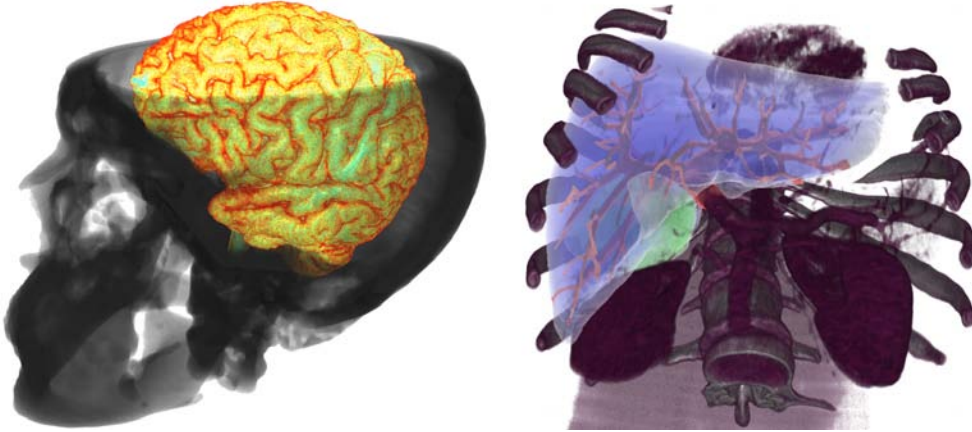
Most relevant scenes for real medical applications are used as test cases C2 (left) and C7 (right). C2 shows a skull acquired as CT scan with a brain acquired as MRI. C7 is a volume of the abdomen, combined with a 10k polygonal model representing the liver surface, a 30k polygonal model representing the liver portal vessel tree and a 5k polygonal model representing a tumor.
